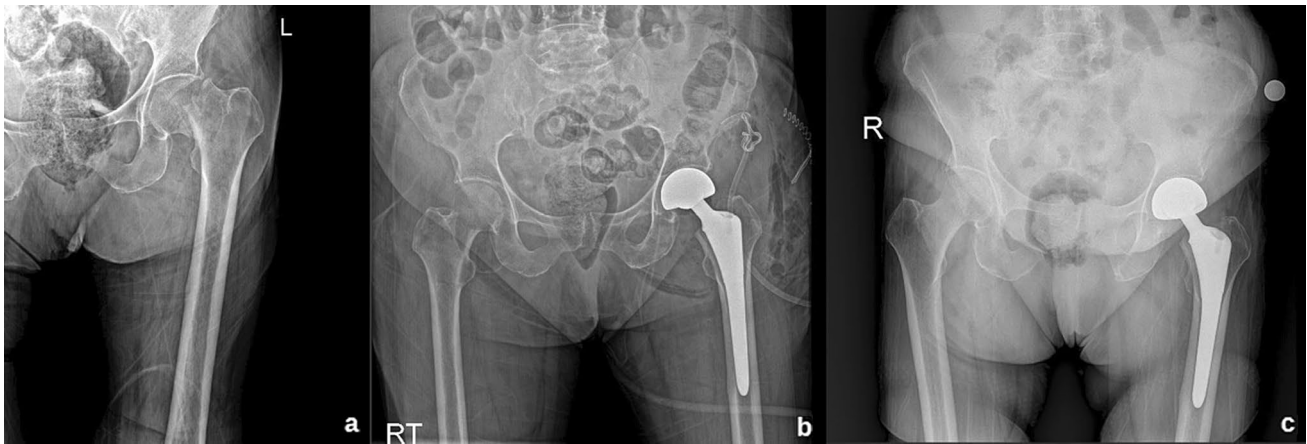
Radiographs (anteroposterior view) of 78-year-old patient with fracture neck of femur on the left side. a Preoperative; b immediately after cementless bipolar hemi-replacement; c 2 years after cementless bipolar hemi-replacement
